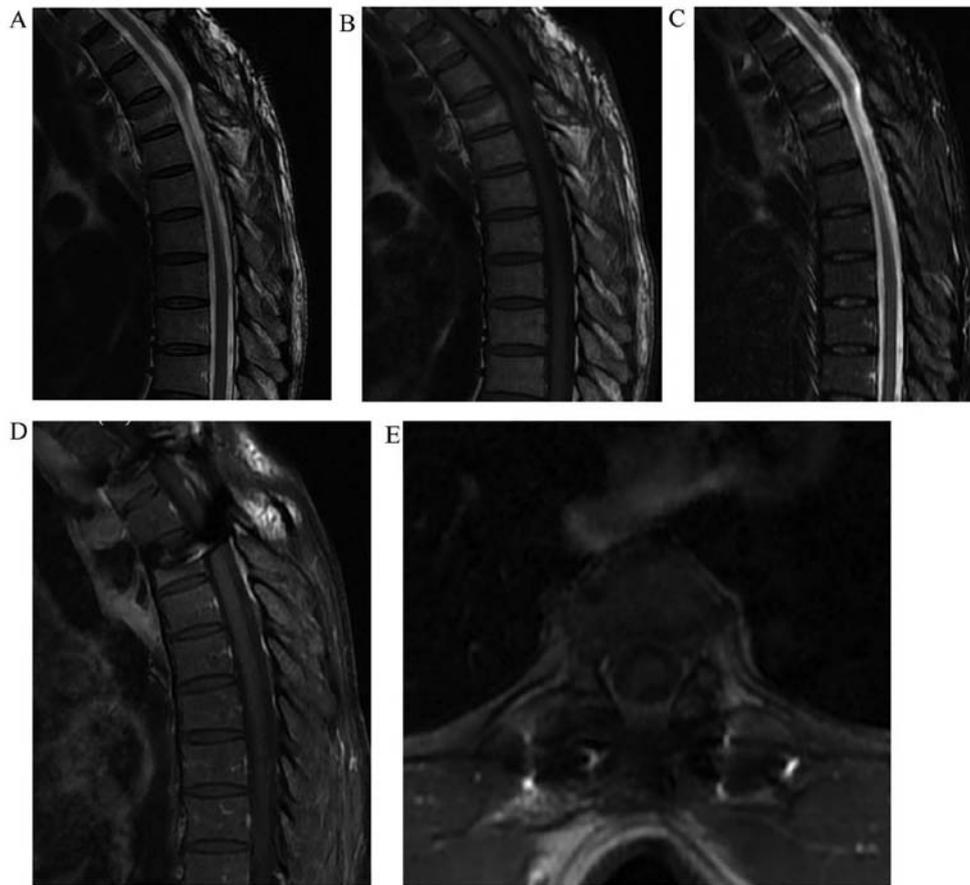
MRI images at 5 years after the second operation. (A) T2-weighted image (TR 2000, TE 222.6), (B) T1-weighted image (TR 385, TE 13.6), (C) Short T1 Inversion Recovery (TR 3402, TE 47.4), (D) enhanced sagittal (TR 376, TE 13.6) and (E) axial T1-weighted image (TR 489, TE 13.2) MRI images indicate no signs of recurrence. TR, repetition time; TE, echo time.
